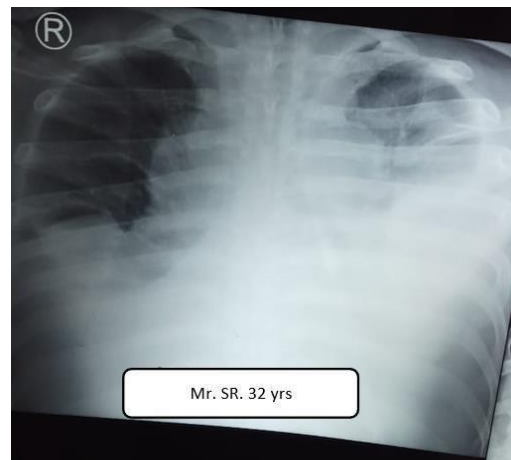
Chest x-ray of homogeneous opacity in lower right and left hemithorax
